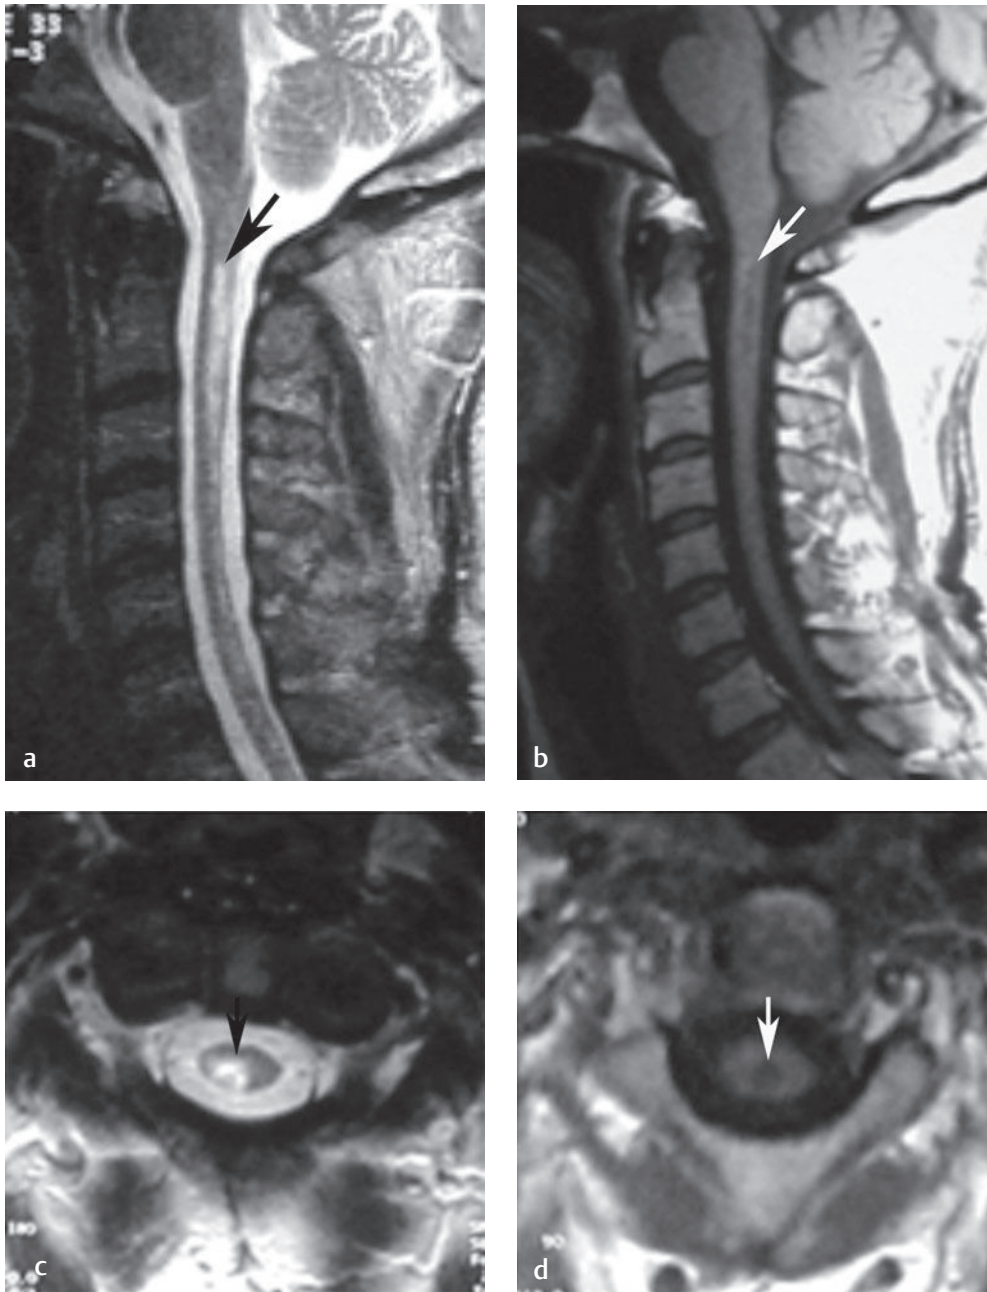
Multiple sclerosis. (a) Sagittal T2-weighted, (b) sagittal T1-weighted, (c) axial T2-weighted, and (d) axial T1-weighted images show a focal region of increased (a, c) and decreased (b, d) signal within the spinal cord (*arrow* on each). In the appropriate clinical setting, these findings are compatible with multiple sclerosis; the diagnosis can be confirmed with lumbar puncture and CSF analysis.[†]
